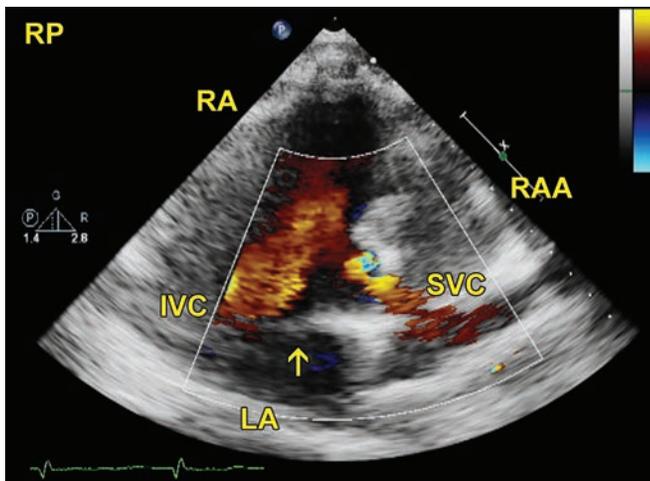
Right parasternal examination. The arrow points to the interatrial septum. Flow signals are seen moving from SVC and IVC into the RA.
